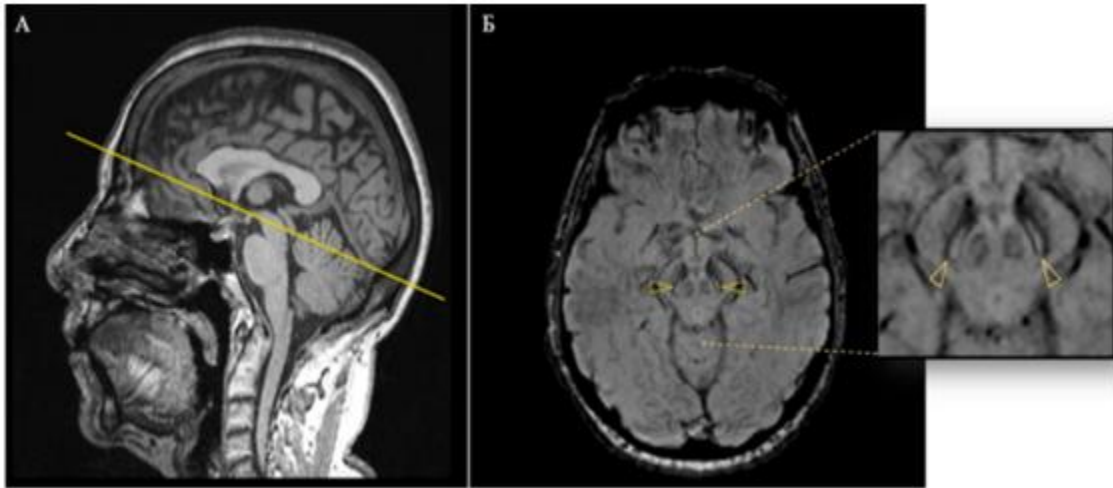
MRI of the substantia nigra in progressive supranuclear palsy: atrophic changes
